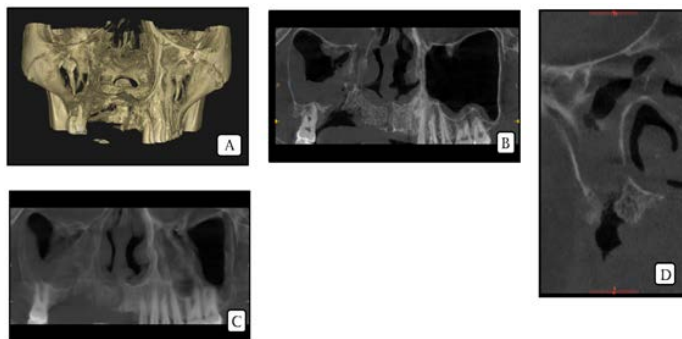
3D CT scan & MRI of face showing destruction of alveolar & anterolateral wall of maxillary bone, nasal floor in right maxilla. MRI also shows radio-opacity involving right maxillary sinus with thickening sinus lining. Perforation of the lateral wall near nasal floor is present.
